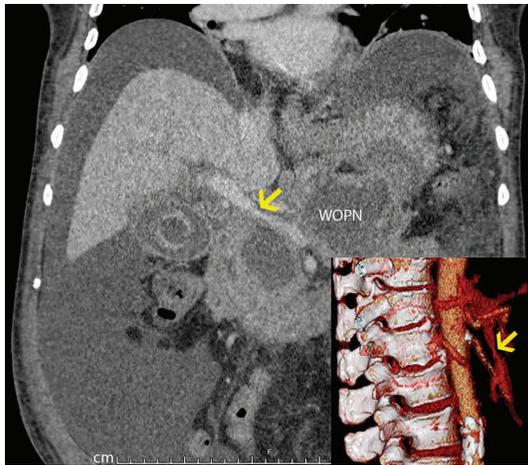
Cross-sectional imaging demonstrating 11×21×9 cm walled-off pancreatic necrosis (WOPN) collection causing main portal vein compression. Note the liver contour and parenchyma appear relatively normal. Inset: Three-dimensional vascular reconstruction of computed tomography images reveals critical stenosis of portal vein related to compression from WOPN
